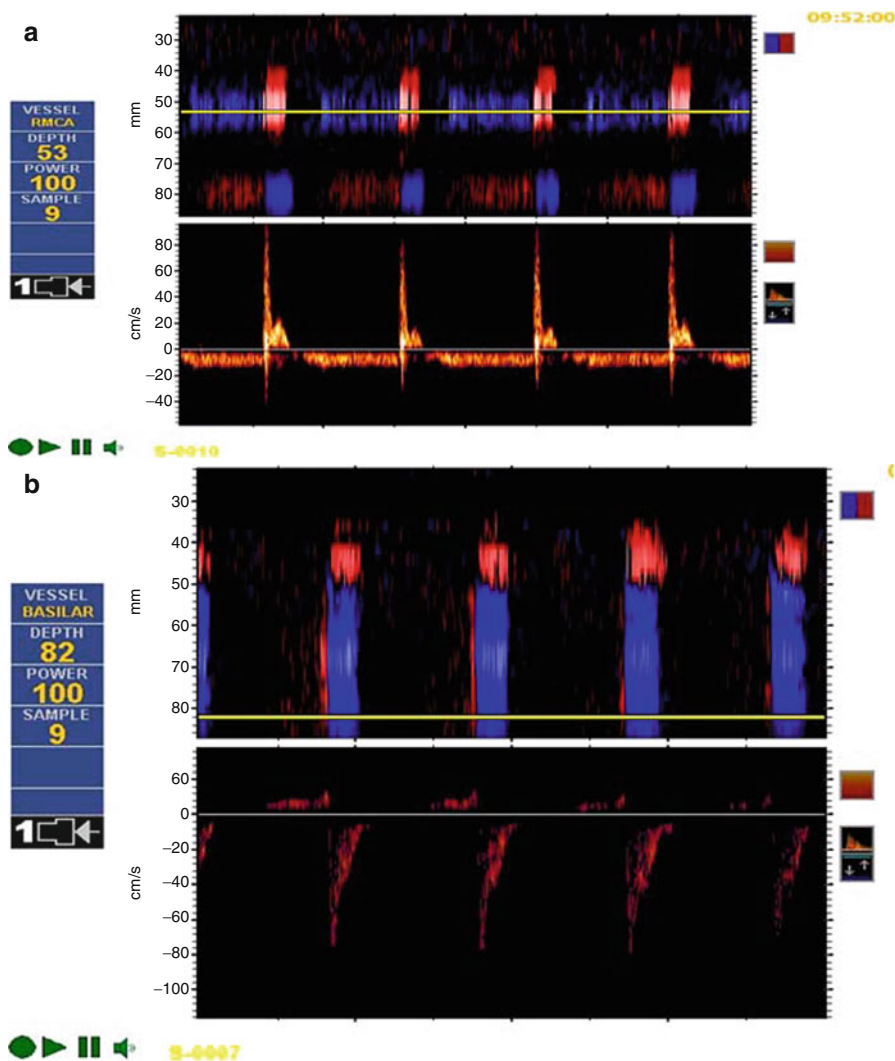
A 54 year-old female patient with intracerebral hemorrhage from large right frontal AVM. Following staged embolization, the patient became unresponsive, hypotensive and progressed to deep coma with fixed and dilated pupils. Computed tomography of the head revealed rehemorrhage and contrast extravasation indicating a small perforation secondary to guide wire manipulation. The initial ICP readings were 40–50 mmHg despite the administration of mannitol, barbiturates and hypertonic saline. Doppler spectral wave forms and color M-mode display of the right middle cerebral artery (a) indicated antegrade flow in systole and retrograde flow in diastole or oscillating flow. TCD reading from the basilar artery (b) demonstrated oscillating flow. Recording of the left extracranial internal carotid artery (c) with spectrum analysis indicating systolic peaks (Images courtesy of Colleen Douville, Swedish Neuroscience Institute, Seattle)
